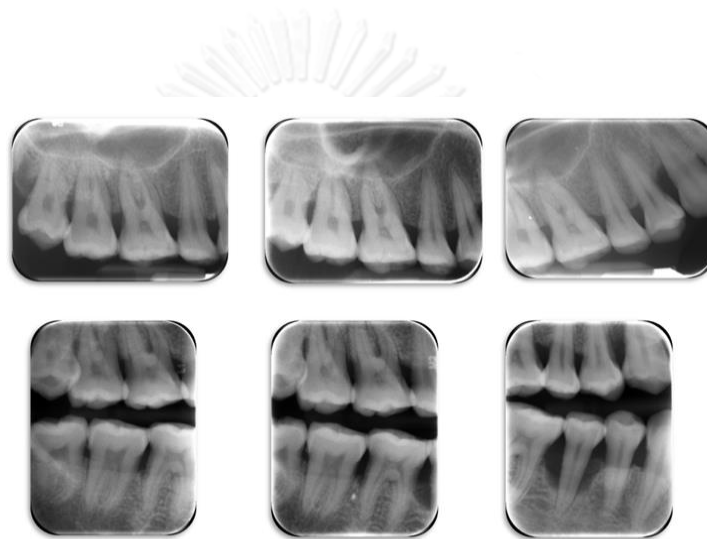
The periapical and the vertical bitewing radiographs of the upper right posterior area.
